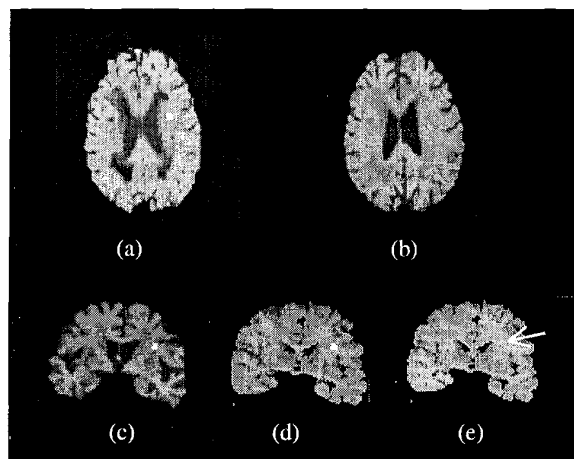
Registration in different orientation. (a) Lesion is marked in white on a T2-weighted transaxial MR slice. (b) Registered T1-weighted transaxial slice derived from the 3D reference volume to match (a) using the 2nd-order polynomial transformation, (c) warped MR section registered to a coronal postmortem slice shown in (d). The lesion found in (a) and translated into (c) is mapped into (d). (e) Original postmortem slice where an arrow indicates an identified lacune.
